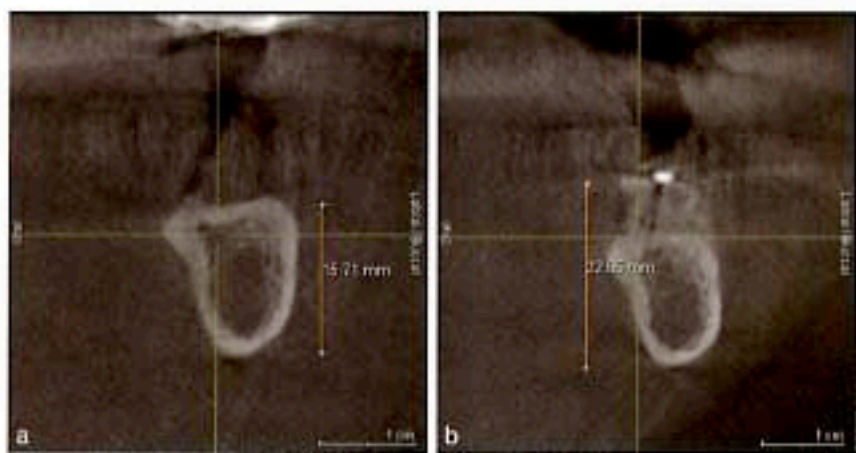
(a) Cone-beam computed tomographic cross section of a resorbed mandible before augmentation. Mandibular height: 15.7 mm. (b) Same section of the same patient, 6 months after augmentation. Mandibular height: 22.6 mm, radiographic bone gain approx. 6.9 mm.
